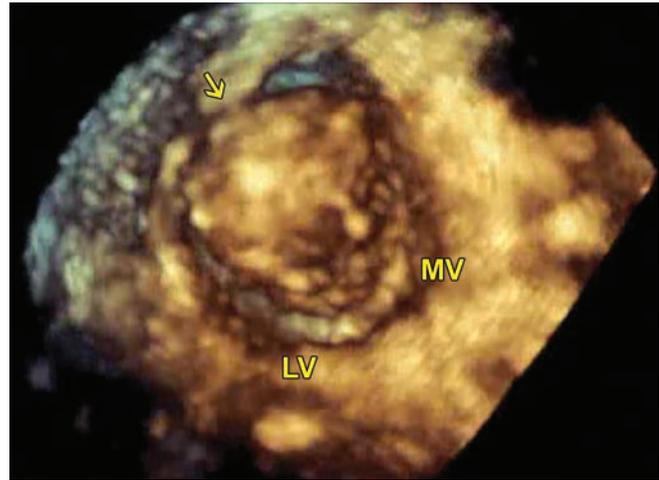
Transesophageal three-dimensional echocardiography rendering of the mitral valve viewed from the left atrium ("surgeon's view"). Arrow points to the myxoma as it is protruding through the mitral valve.
